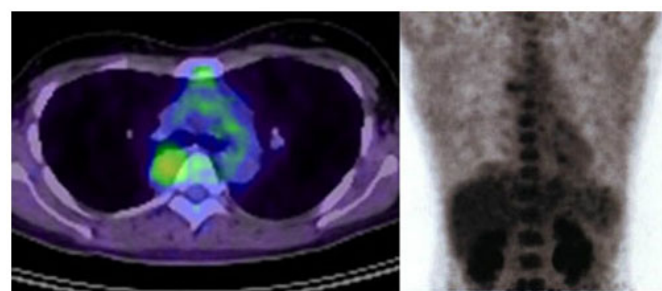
Positron-emission tomography in case 1. Abnormal slight uptake (SUV_{max} = 2.87 [60 min]/2.46 [120 min]) is seen in the tumor.
